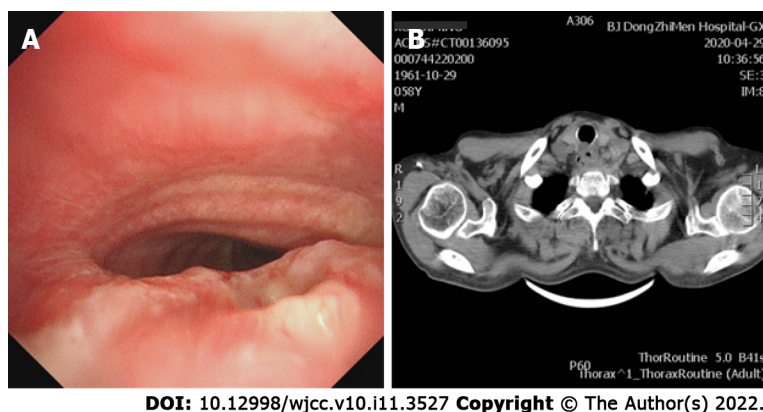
Tracheoesophageal fistula and narrowing of the main bronchus. A: Bronchoscopy image; B: Computed tomography image.
